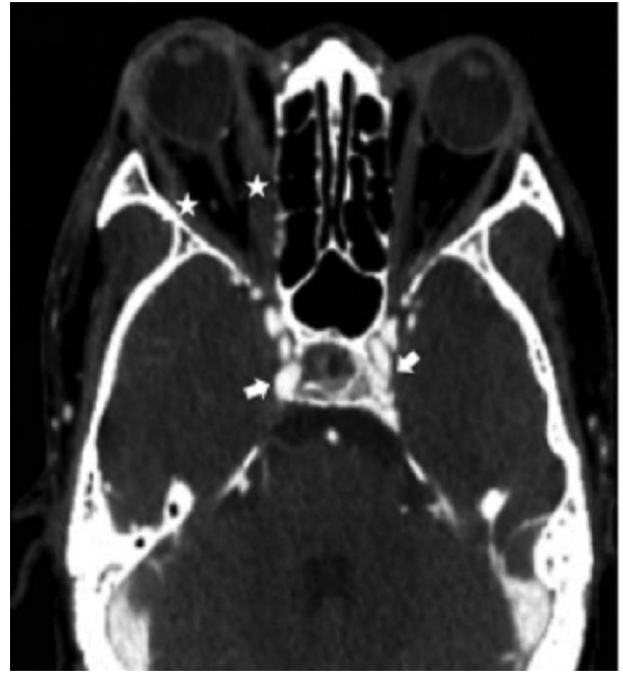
Computed tomography angiography (CTA) shows more obvious extraocular and intraocular muscle enlargement on the right (white stars), and confirms the connection between the internal carotid artery and the cavernous sinus on both sides (white arrows).
